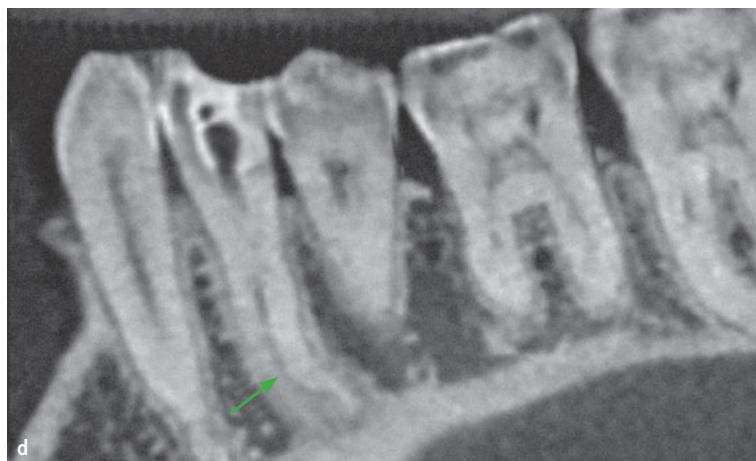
CBCT images. (a) Coronal third axial section of the root. (b and d) The green arrow indicates the lingual invagination groove in axial (b) and sagittal section (d). (c) Axial section of the apical third of the root.
